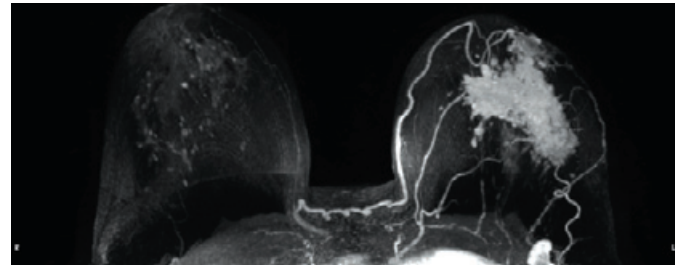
Breast MRI - 3D image showing mass in the left breast with abnormal lymph nodes in the axilla.
